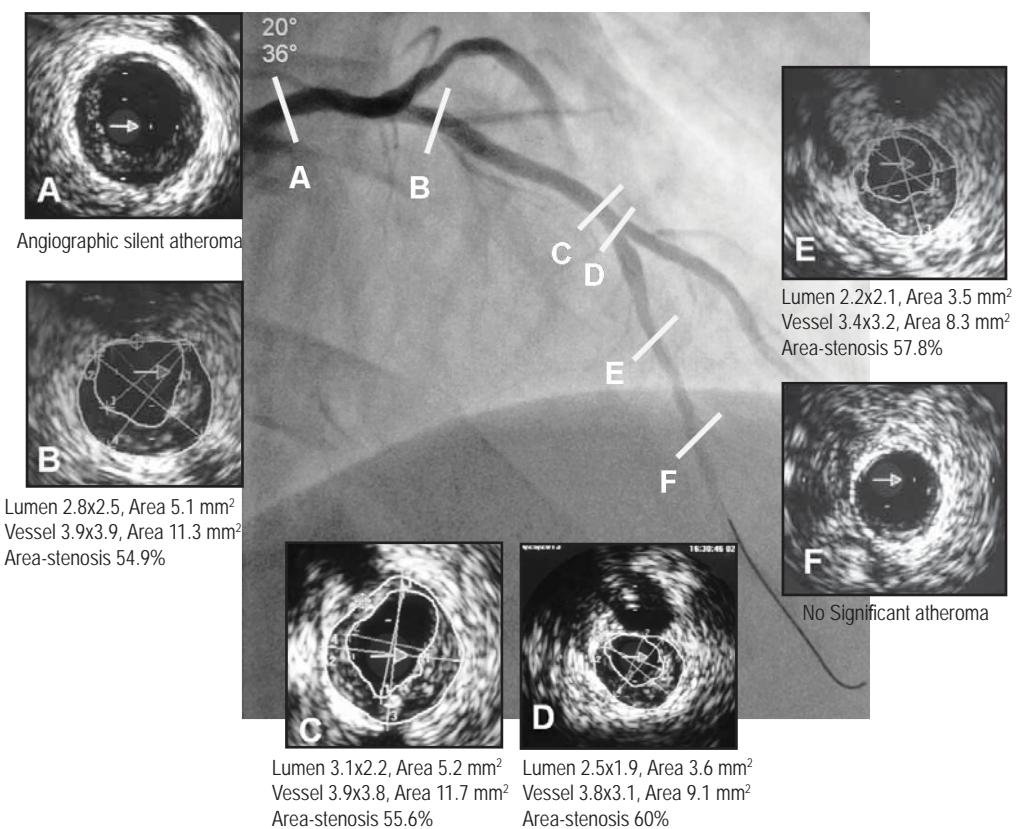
Intravascular ultrasound imaging showed an angiographic silent atheroma from 2 to 12 o'clock in the left main, (A) and proximal LAD artery (B). At the mid LAD segment, the lumen (arrow sign) shape was elliptical since it was surrounded by an eccentric fibro-lipid atheroma, causing an area stenosis of 55.6% and 60% (C &D). Similar lesion was observed along the vaso-spastic segment (E). However, there was no significant plaque burden in the distal LAD (F).
